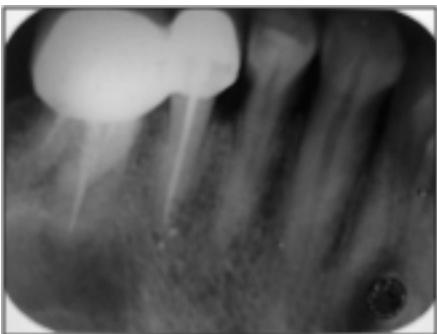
Radiograph after fragment was removed
